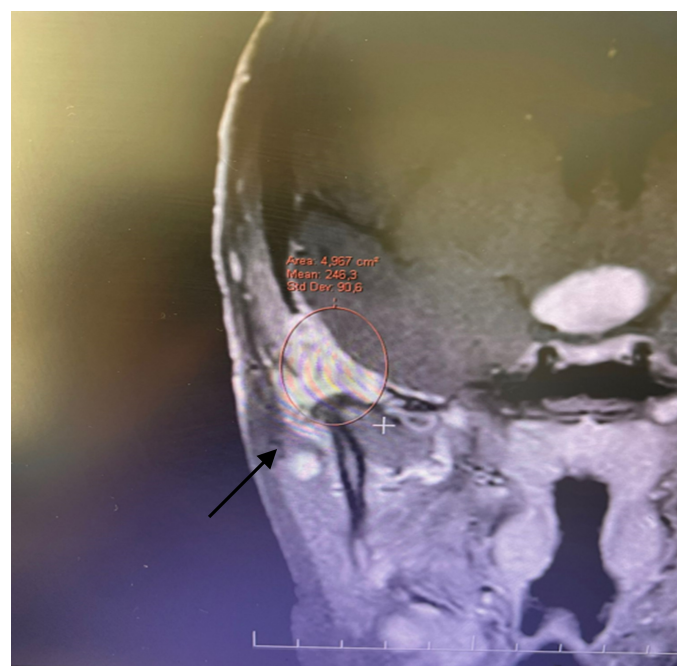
Heterogeneous hyperintense signal increases in the left mastoid region in pituitary magnetic resonance imaging.
